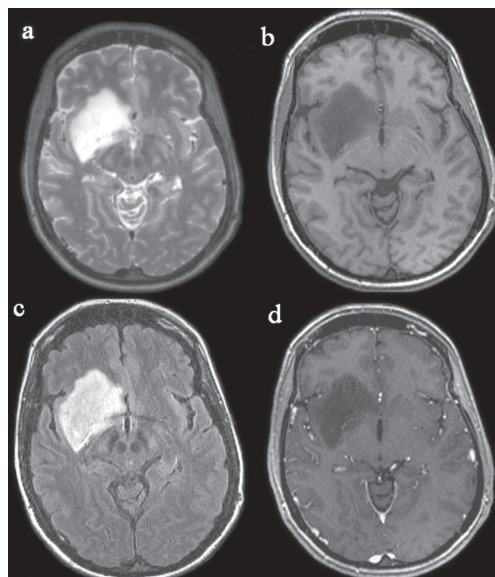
Low-grade glioma. Axial T2-weighted image (a) demonstrates a homogenously hyperintense mass in the insular region extending into the right frontal lobe. This mass is well circumscribed with minimal mass effect and edema that appears hypointense on T1-weighted image (b) and hyperintense on FLAIR image (c). There is no evidence of abnormal contrast enhancement on the post contrast T1-weighted image (d)
